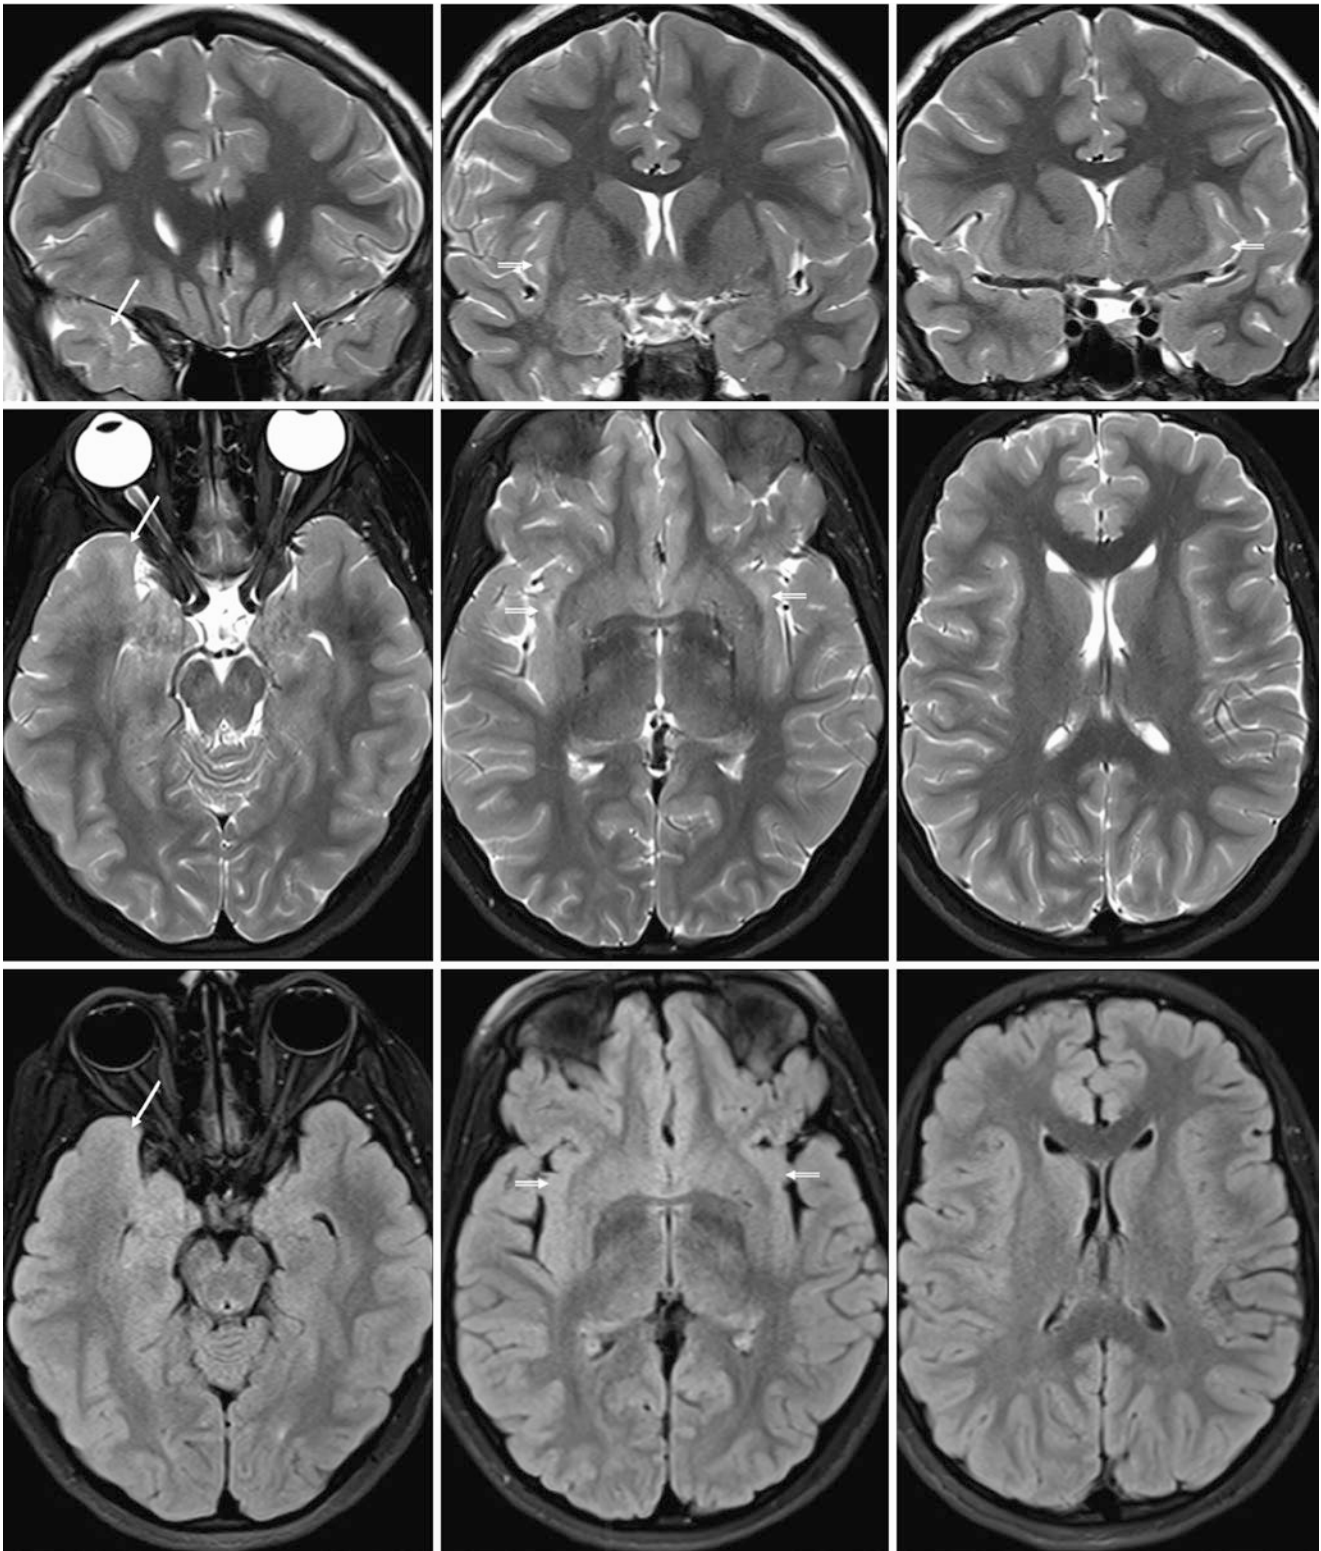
An 11-year-old with a sleep disorder had a normal 3T MRI. *Top row:* Coronal SE T2WIs depict bilateral, subtle ATWM-SCWM terminal zones (*thin arrows*), which are quite focal. There are also bilateral small terminal zones within the SIWM. *Middle row:* Axial SE T2WIs further demonstrate the subtle terminal zones within the ATWM-SCWM terminal zones and SIWM (*beveled arrows*). The
